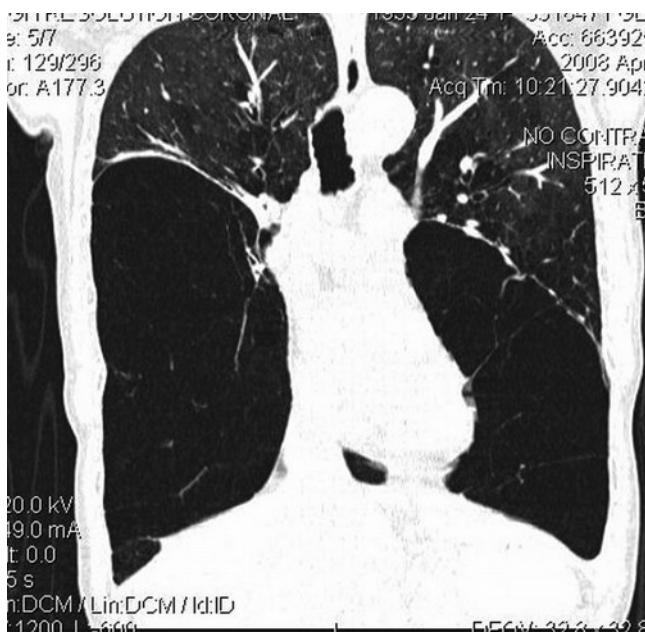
Coronal CT scan of a patient with bilateral giant lower lobe bullae. During one-lung ventilation for bullectomy, the risk of contralateral bulla rupture and tension pneumothorax must always be kept in mind.
